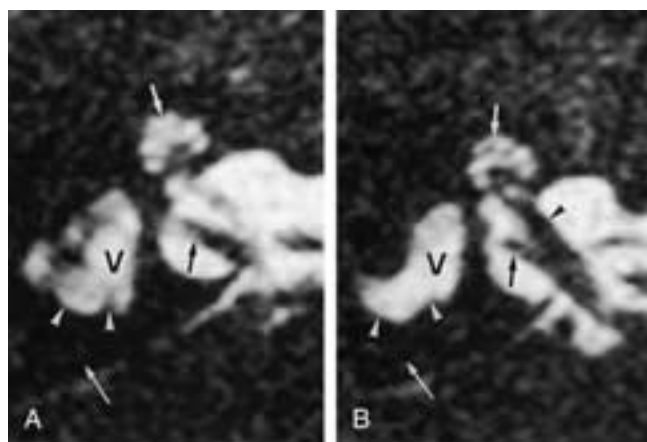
Globular enlargement of the utriculosaccular structures in association with semicircular duct malformations. A, Axial 0.7 mm thick T2-weighted gradient-echo (3DFT-CISS) images through the upper part of the right utriculosaccular structures. Enlarged fluid-filled utriculosaccular structures can be seen inside the vestibule (V). The lateral semicircular duct (white arrowheads) is irregular and too thick and is partially incorporated in the large vestibule. The posterior semicircular duct is absent (long white arrow). Normal cochlea (small white arrow) and inferior vestibular branch of the VCN (small black arrow). B, Axial T2-weighted gradient-echo image through the inferior part of the utriculosaccular structures. The posterior part of the lateral semicircular duct is too large (white arrowheads). The posterior semicircular duct is absent (long white arrow), and the utriculosaccular structures inside the vestibule (V) are still a little too large. Normal cochlea (small white arrow), inferior vestibular (small black arrow), and cochlear (black arrowhead) branch of the VCN.
